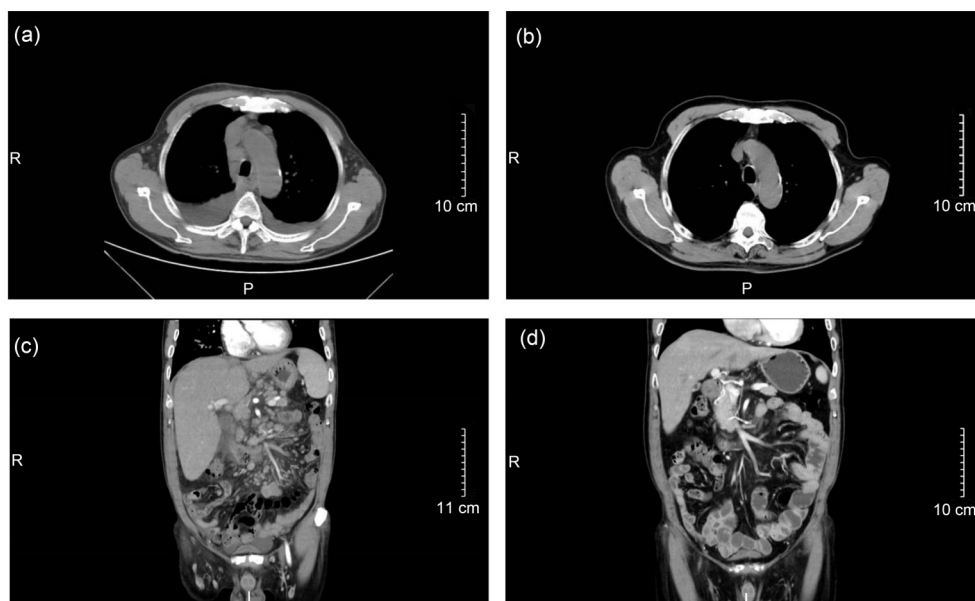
Chest and abdominal CT of Case 2. (a) Multiple axillary and mediastinal lymphadenopathy before treatment in May 2019; (b) No significant axillary or mediastinal lymph node enlargement was observed after L-CHOP therapies in December 2019; (c) Multiple lymphadenopathy in the lesser omentum, mesentery, and retroperitoneum before treatment in May 2019; (d) No significant lymph node enlargement was observed in the lesser omentum, mesentery, or retroperitoneum after L-CHOP therapies in December 2019. CT: computed tomography; L-CHOP: lenalidomide, cyclophosphamide, doxorubicin, vinorelbine, and prednisone.
